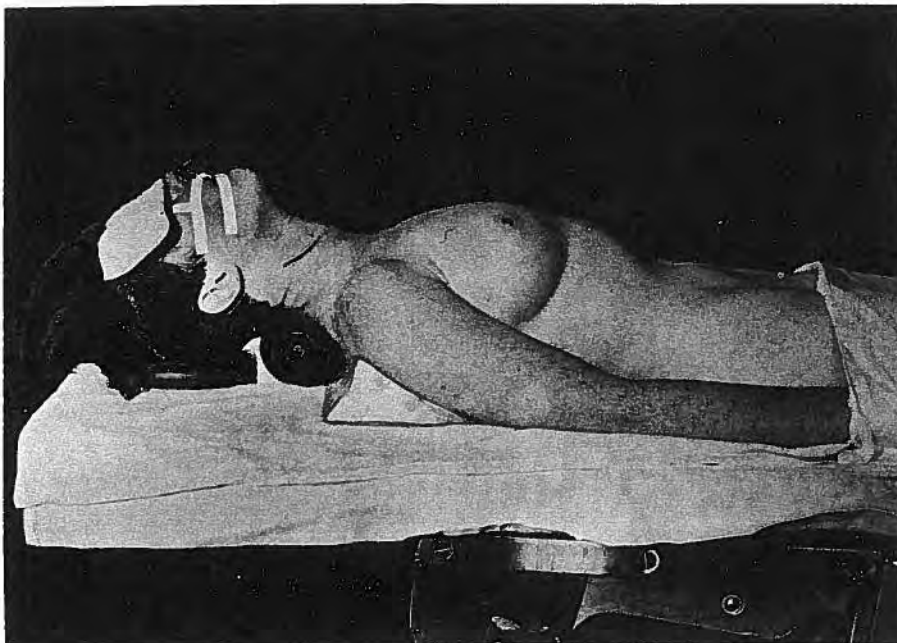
A photograph of a patient postured on the operating table for anterior cervical interbody fusion. Note the triangular-shaped pillow underneath the shoulders, the rolled towel (in black) under the neck, and the rubber ring on which the occiput rests. The endotracheal tube and the reinforced rubber airway adjacent to it are strapped to the patient's face. Note the pad covering the eyes, to prevent pressure on the orbits during surgery. Assistants have been known to press on the eyes during anterior cervical interbody fusion operations. *Irreparable ocular damage has been reported from this cause.* Note also the outline of the hemi-collar incision extending from the anterior border of the sterno-mastoid muscle to just behind the mid-line. Through this incision two or three cervical discs can be exposed. For exposure of the disc between C2 and C3 vertebral bodies, the incision needs to be placed in the sub-mandibular region, care being taken to avoid damaging the mandibular branch of the facial nerve. Note that both arms are by the patient's side, to allow traction on the hands for lowering the shoulders while control X-rays are being taken during the operation
